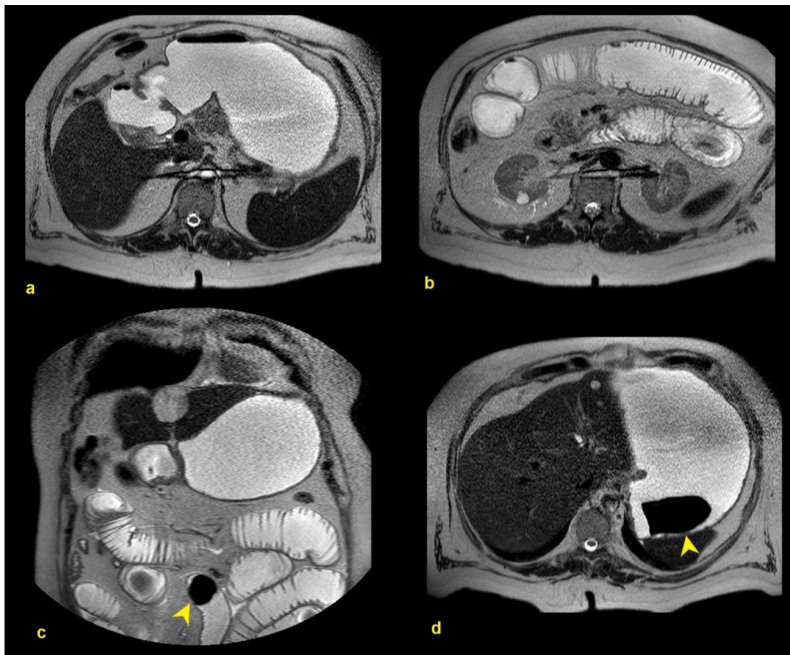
T2-weighted axial (a, b, d) and coronal (c) images of an MRI performed one week later. No gallstones were identified in the duodenum (a). Instead, several dilated fluid-filled small bowel loops could now be observed (b). Even though the MRI did not include the pelvis, the cause of the obstruction was a large gallstone that was found in the ileum (c, arrowhead). In the stomach, another gallstone could be appreciated (d, arrowhead).
